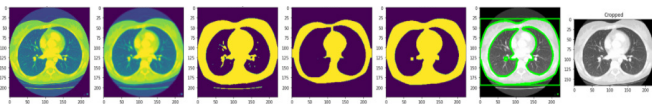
The stages of an automatic lung field crop on a sample chest CT scan. After ensuring the image has only one color channel (grayscale), smoothing the image out, and setting a pixel threshold to create a binary image, erosion and dilation remove irrelevant features. The image is then cropped to the bounding box created around the contour with the largest area.
